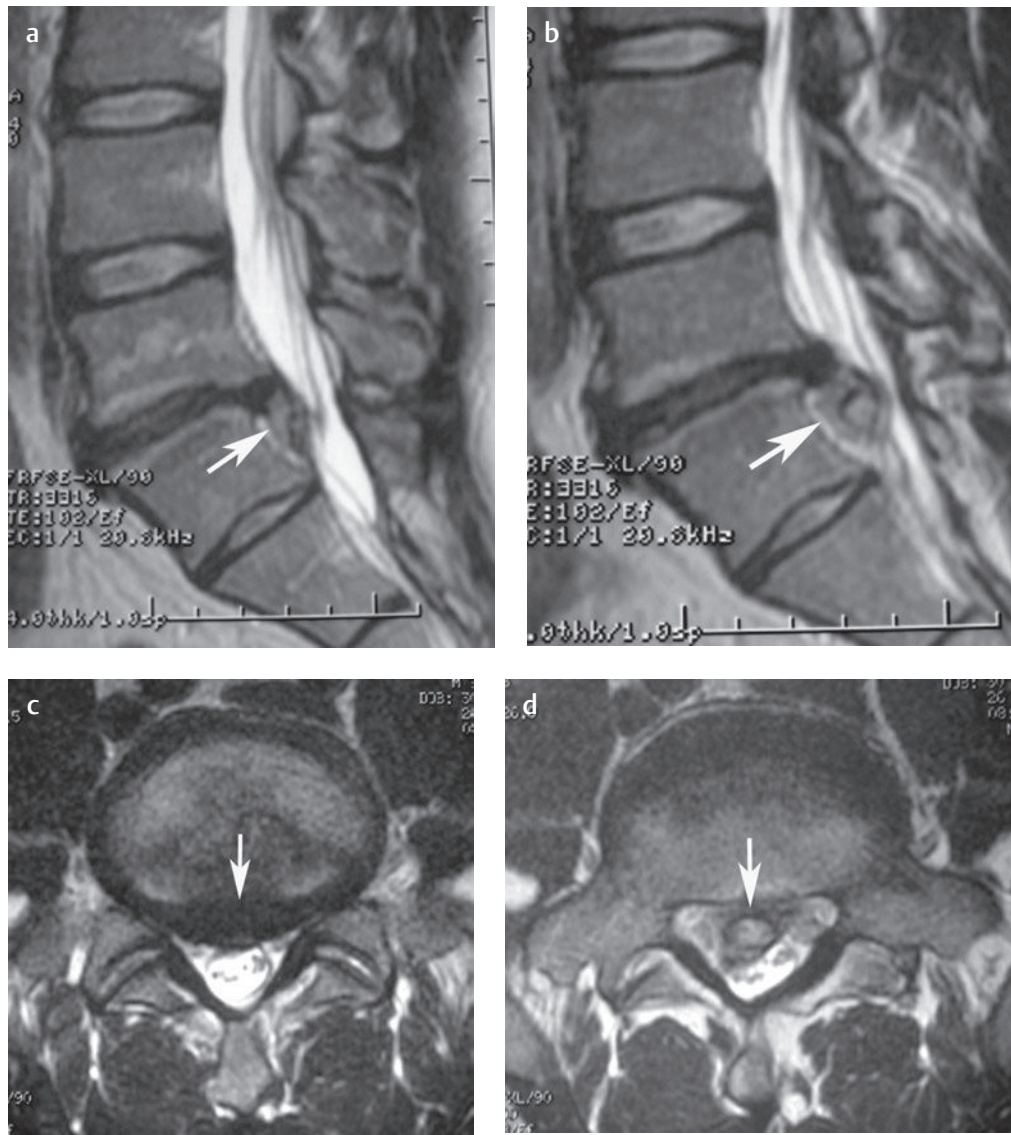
Lumbar disc extrusion. (a) Midline sagittal and (b) parasagittal T2-weighted images show a large disc extrusion at the L4-L5 level and distal migration of the disc fragment (arrow on each) to behind the L5 vertebral body in a patient with transitional lumbosacral anatomy. Note the advanced degenerative disc disease at this level. (c) An axial T2-weighted image at the level of the L4-L5 disc shows what appears to be a central disc bulge (arrow). (d) However, an axial T2-weighted image at the L5 vertebral body level shows the disc extrusion (arrow).[†]
